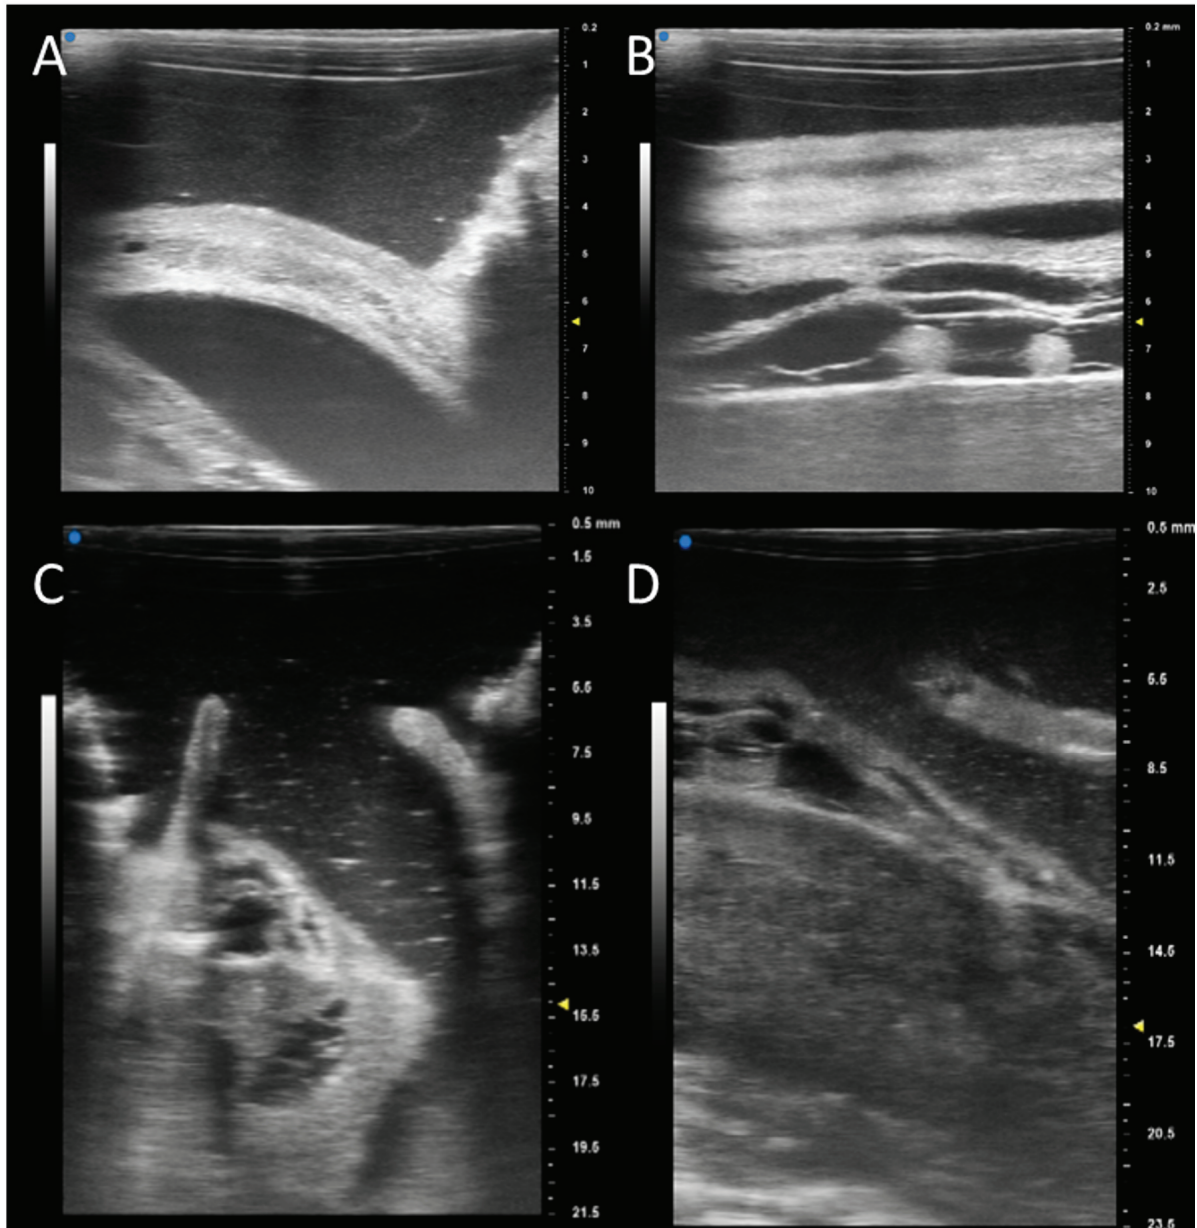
Patient 1: Intraoperative ultrasound – A,B) Axial and longitudinal intraoperative high frequency micro-ultrasound images acquired using a 50 MHz central frequency probe. Dura partially intact. C,D) Axial and longitudinal intra-operative high frequency micro-ultrasound images acquired using a 30 MHz central frequency probe. Dura has been removed. Note the trade-off in spatial resolution vs. depth as a function of frequency.
